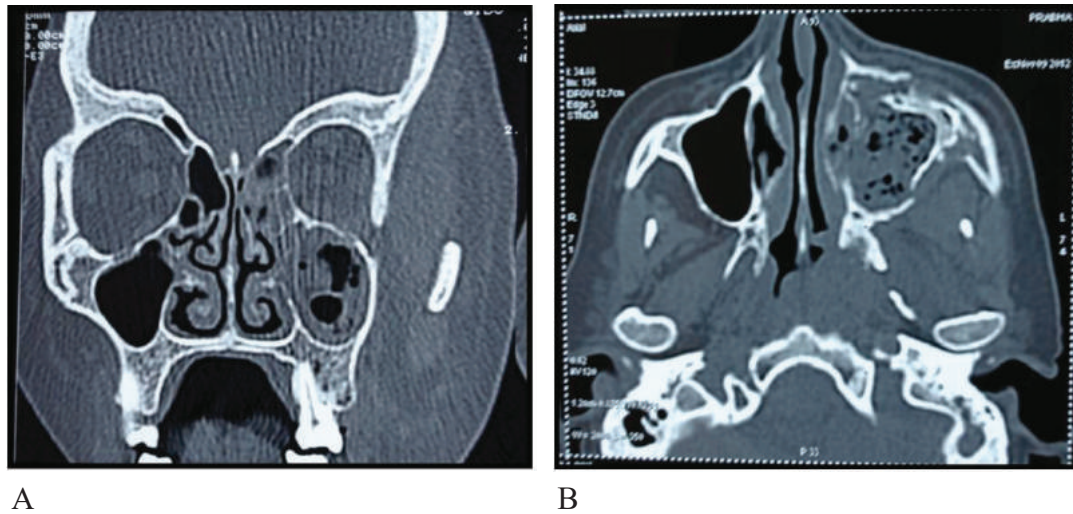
(a) Coronal view of CT showing involvement of left maxillary sinus, nasal conchae, and ethmoidal sinus extending up to frontal sinus; (b) Axial view of CT showing destruction of posterior, medial, and anterior walls of left maxillary sinus.¹⁶
